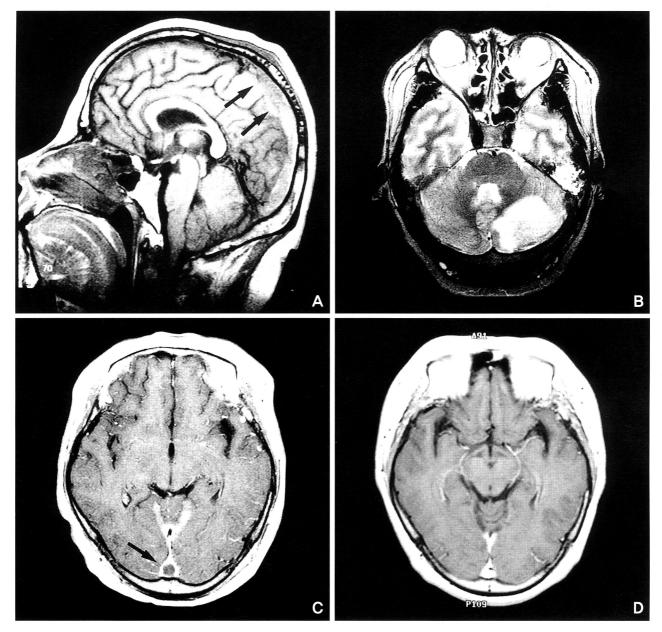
Case 1. A: Sagittal T1-weighted MR image shows isointense lesion (arrows) in the superior sagittal sinus. B: Axial T2-weighted MR image shows diffuse high signal intensity in the left cerebellar hemisphere. C: Axial T1-weighted MR image shows 'empty delta sign' (arrow). D: Follow-up (3 month later) MR image shows the disappearance of the thrombus in the sagittal sinus.
